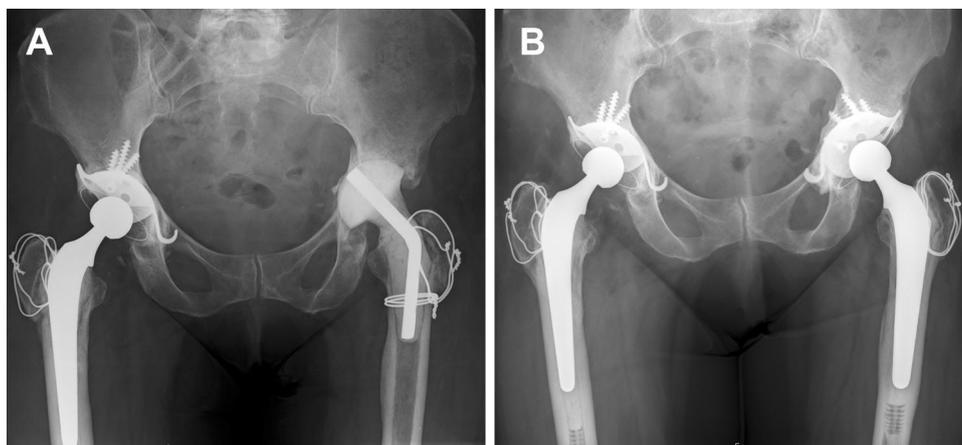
Radiographs of a female patient with medical history of bilateral synchronic periprosthetic joint infection of the hips at the age of 58 years. Infection was treated with two-staged revision and implantation of antibiotic-loaded cement spacers. The right hip associated with an AAOS II acetabular defect was re-implanted first (a). In a second surgery the left hip was re-implanted. The acetabular
